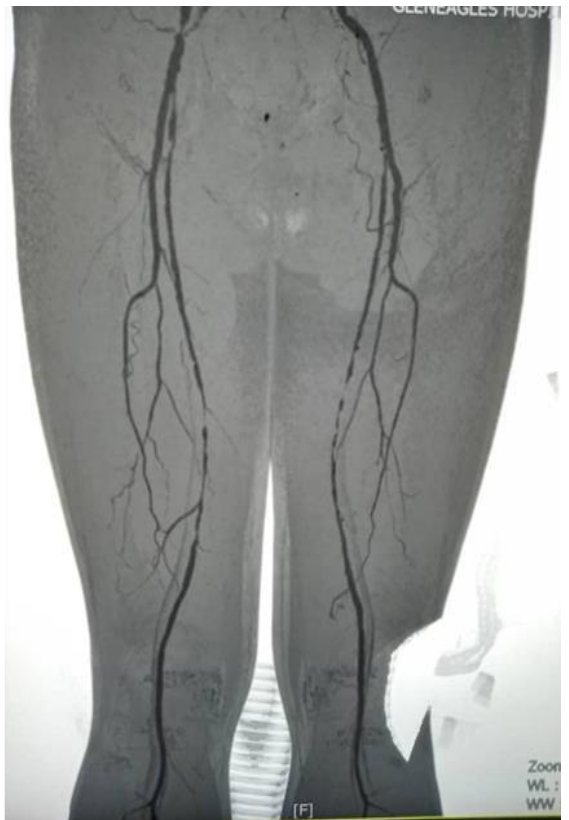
CT angiogram LL : multiple severe stenosis in the abdominal aorta, bilateral iliac and common femoral arteries extending to the upper popliteal arteries.
